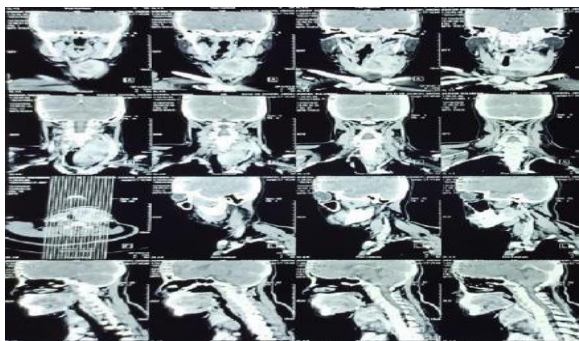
Neck CT scan showing multiple right thyroid lesions, left thyroid enlargement and multiple left thyroid lesions, multiple nodules in the isthmus, and multiple lymph nodes in the colli, submental, and submandibular regions bilaterally.
